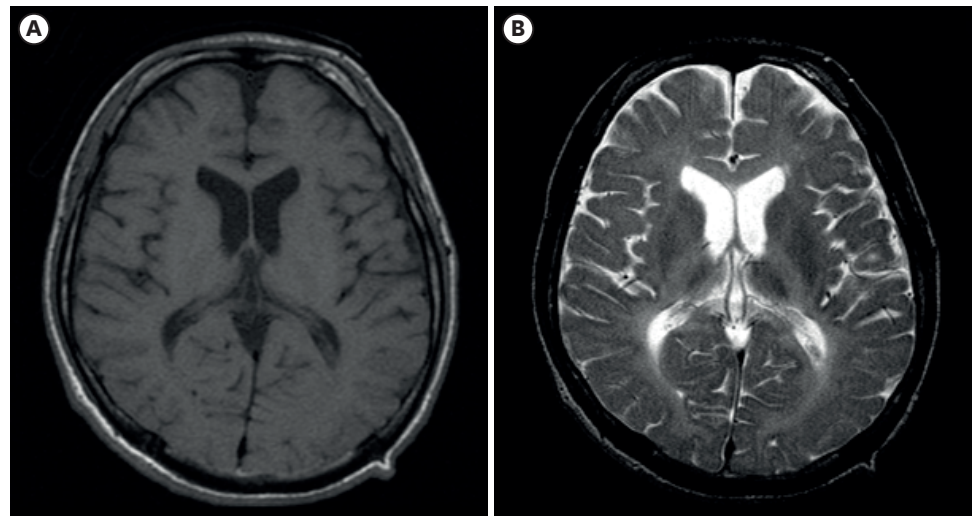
Findings of brain MRI in this patient. T1-weighted MRI exhibits no signal contrast between white matter and gray matter (A), and T2-weighted MRI reveals diffuse T2 high signal intensity in bilateral deep and subcortical white matter (B). MRI, magnetic resonance imaging.
